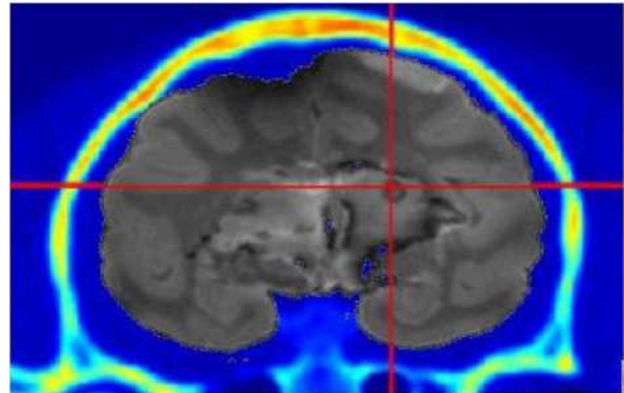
Repositioning between MRI image and the point source chosen on the CT-scan.
